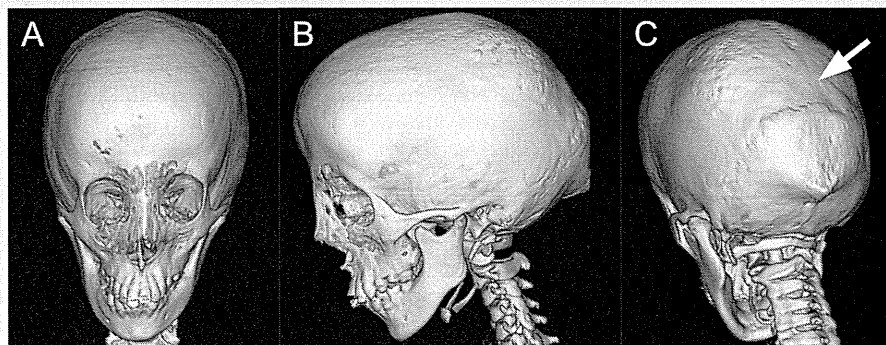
Cranial computed tomography with three-dimensional reconstruction. Note the prominent forehead and marked scaphocephaly on the frontal view (A) and lateral view (B). A partial craniosynostosis of the posterior sagittal suture is visible (arrow, C).
